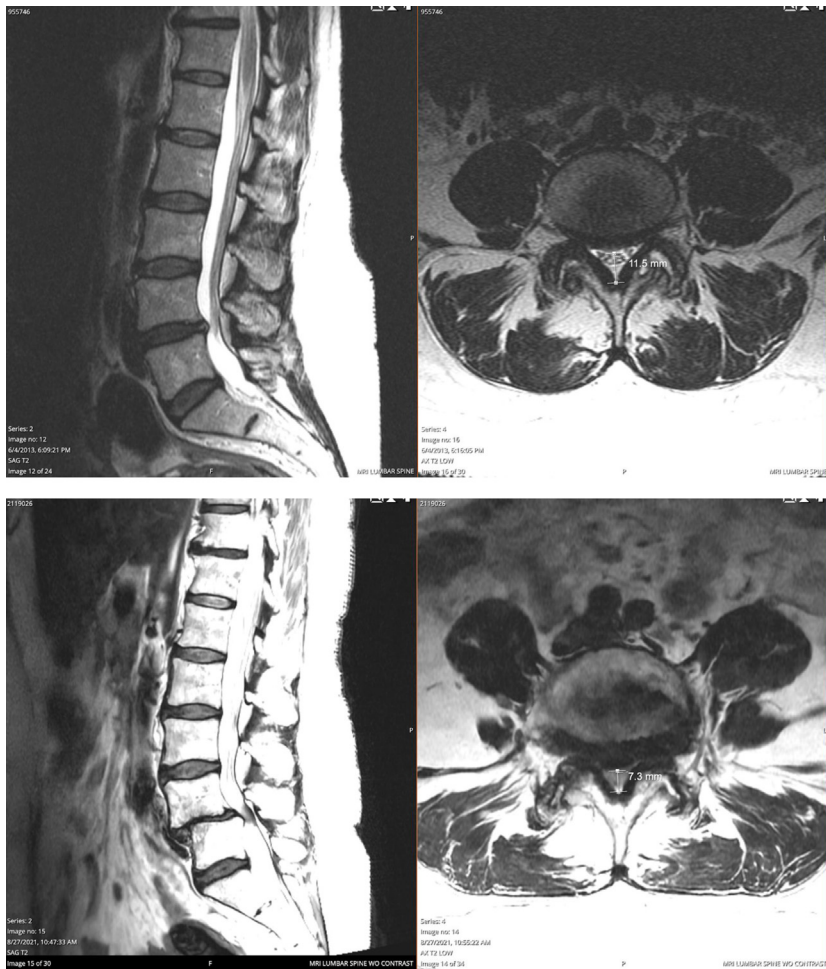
These are MRI images of a patient of mine demonstrating the “degenerative cascade.” The MRI images on the left are T2- sagittal images of the lumbar spine and on the right are T2-axial images through the L4-5 level. The two MRI images on the top are from 2013. The two MRI images on the bottom are from 2021. Notice how the L4-5 disc has completely degenerated over time causing progressive narrowing of the spinal canal (spinal stenosis).
